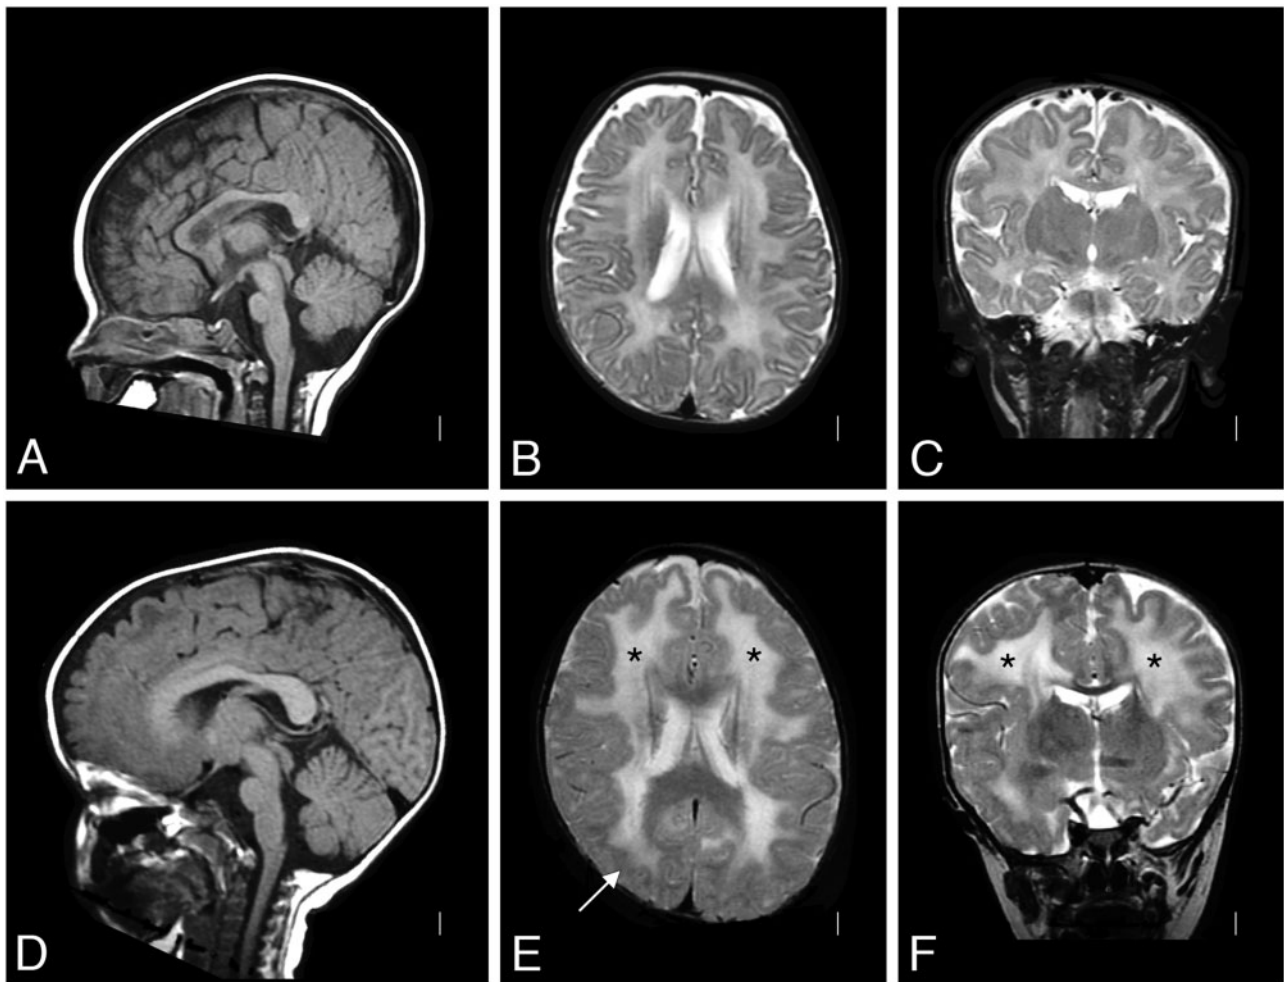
Brain MRI of Patient 1. A T2-weighted brain MRI at 4 months of age was interpreted as normal (A: sagittal, B: coronal, and C: axial); the white matter signal was developmentally appropriate. By 2 years of age (D: sagittal, E: coronal, and F: axial), a repeat T2-weighted MRI showed white matter changes (* in E and F) with only subtle structural abnormalities (arrow in E). MRI, magnetic resonance imaging.
